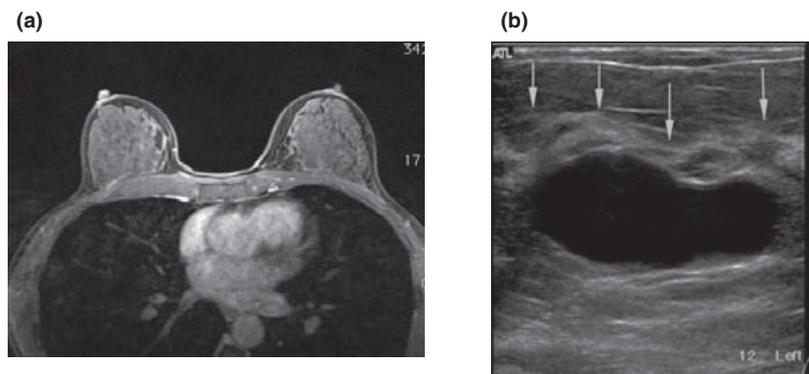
MRI (a) and breast ultrasound (b) showing dense breast tissue and a clear plane between the breast and the subcutaneous fat.
